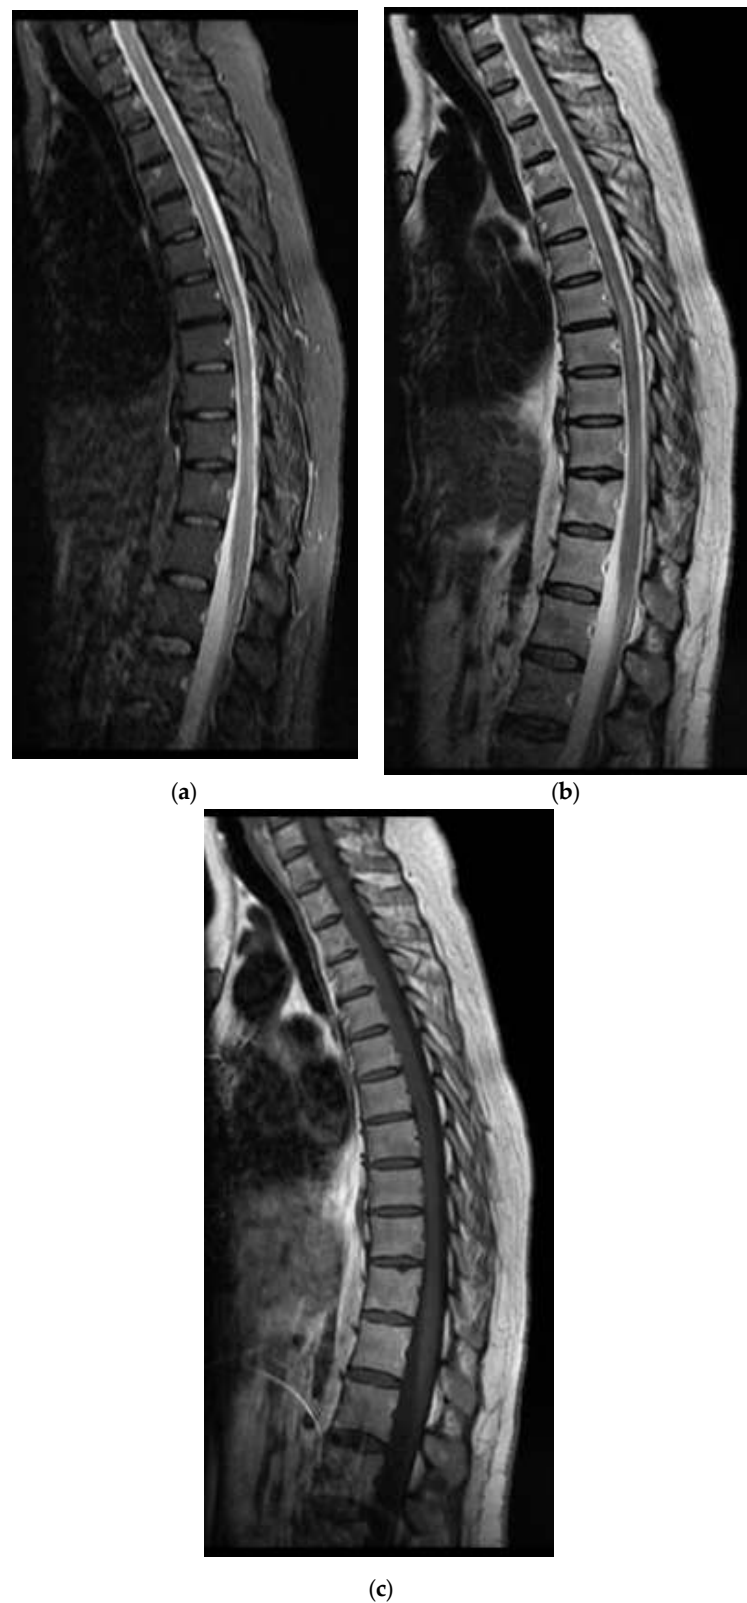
MRI images of the Case 1 patient show inaccurate delimited discrete hyperintense foci on T2-STIR (a,b), hypointense T1 (c), disposed at the level of lateral coordinates of the marrow corresponding to T6–T10 myeloma; thoracic intramedullary lesions with suggestive characters for an inflammatory-infectious sublayer.
